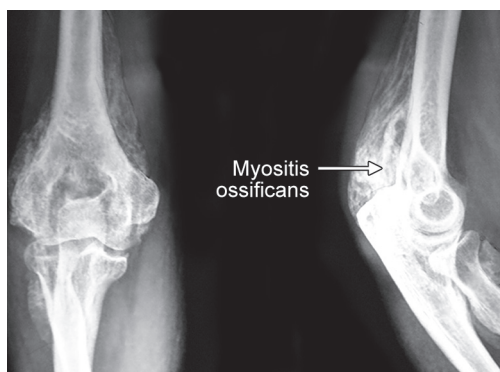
X-ray: Myositis ossificans (elbow)
